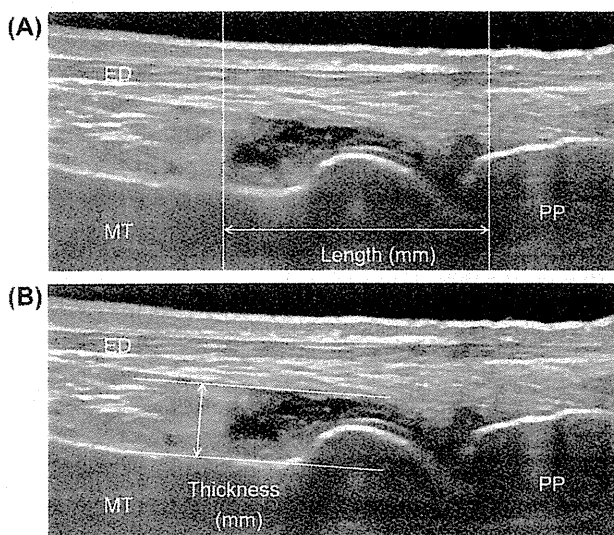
Ultrasonographic measurement of length and thickness of intraarticular low-echoic synovial area in metatarsophalangeal joint. (A) Measurement of length. (B) Measurement of thickness. ED, extensor digitorum; MT, metatarsal; PP, proximal phalanx.
